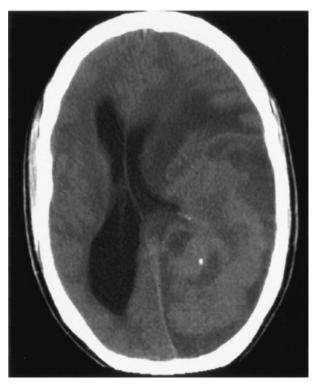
CT scan of the brain. Axial precontrast scan shows a large, isoattenuated left temporoparieto-occipital mass with central hypoattenuated areas of necrosis and one focal calcification.
